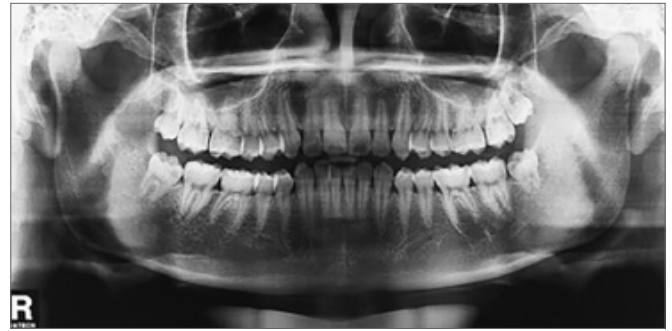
Panoramic radiograph showing a radiolucent circumscribed lesion in the right coronoid process of the mandible.
